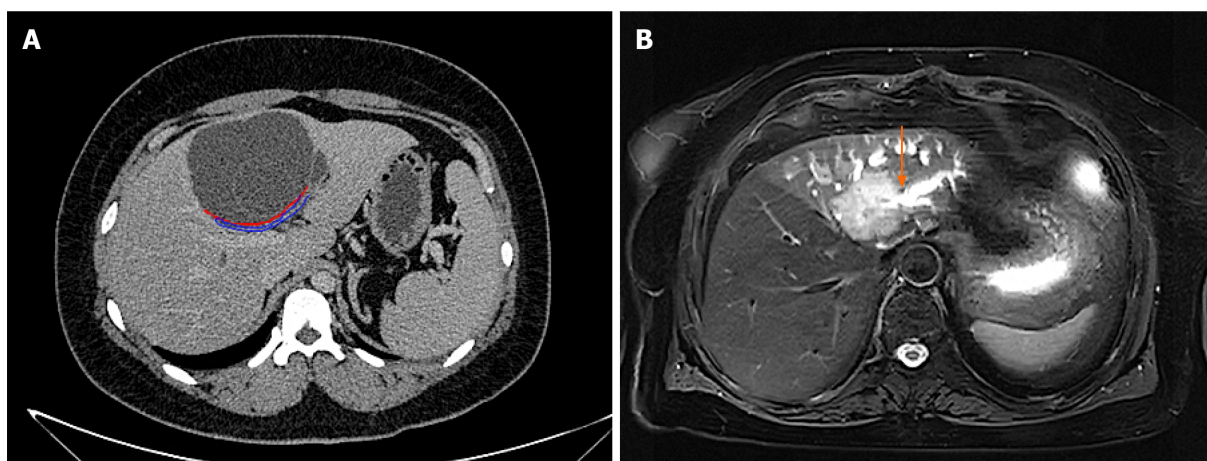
Magnetic resonance imaging of patients with intrahepatic bile duct papilloma. Orange arrows indicate solid components floating in cystic lesions.
